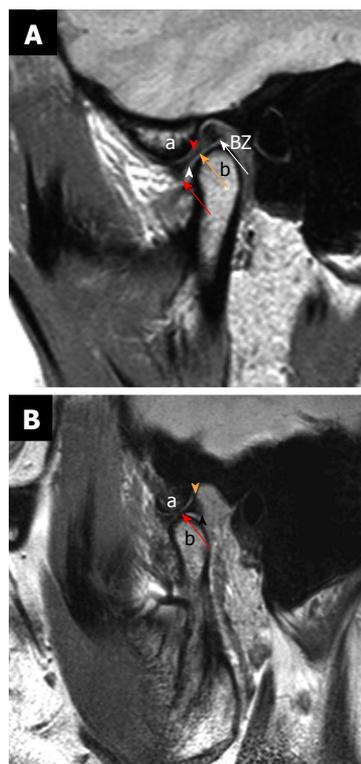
Normal anatomy. Sagittal proton density weighted closed mouth and open mouth view of magnetic resonance imaging. A: On the closed mouth view, the disk is located posterior to the articular eminence (the letter, a). It can be noted that the “bow-tie” shape of the disk: Thicker anterior band (red arrow) and posterior band (white arrow) with a thinner central zone (orange arrow). Bilaminar zone (BZ) is located posterior to the posterior band. It can also be noted that the inferior joint compartment (white arrowhead) between the disk and the mandibular condyle (the letter, b) and superior joint compartment (red arrowhead) between the articular eminence and the disk; B: On the open mouth view (in a different patient), the thinner intermediate zone (red arrow) of the disk is interposed between the articular eminence (the letter, a) and the condylar head (the letter, b) in a “bow-tie” fashion. Orange arrowhead demonstrates temporal lamina and black arrowhead indicate inferior lamina.
